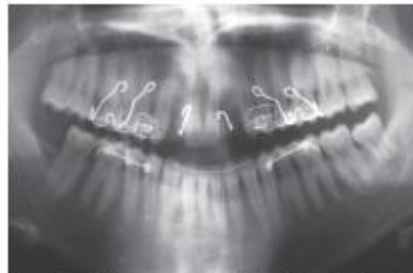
Orthopantomography with orthodontic retainer, before surgery
